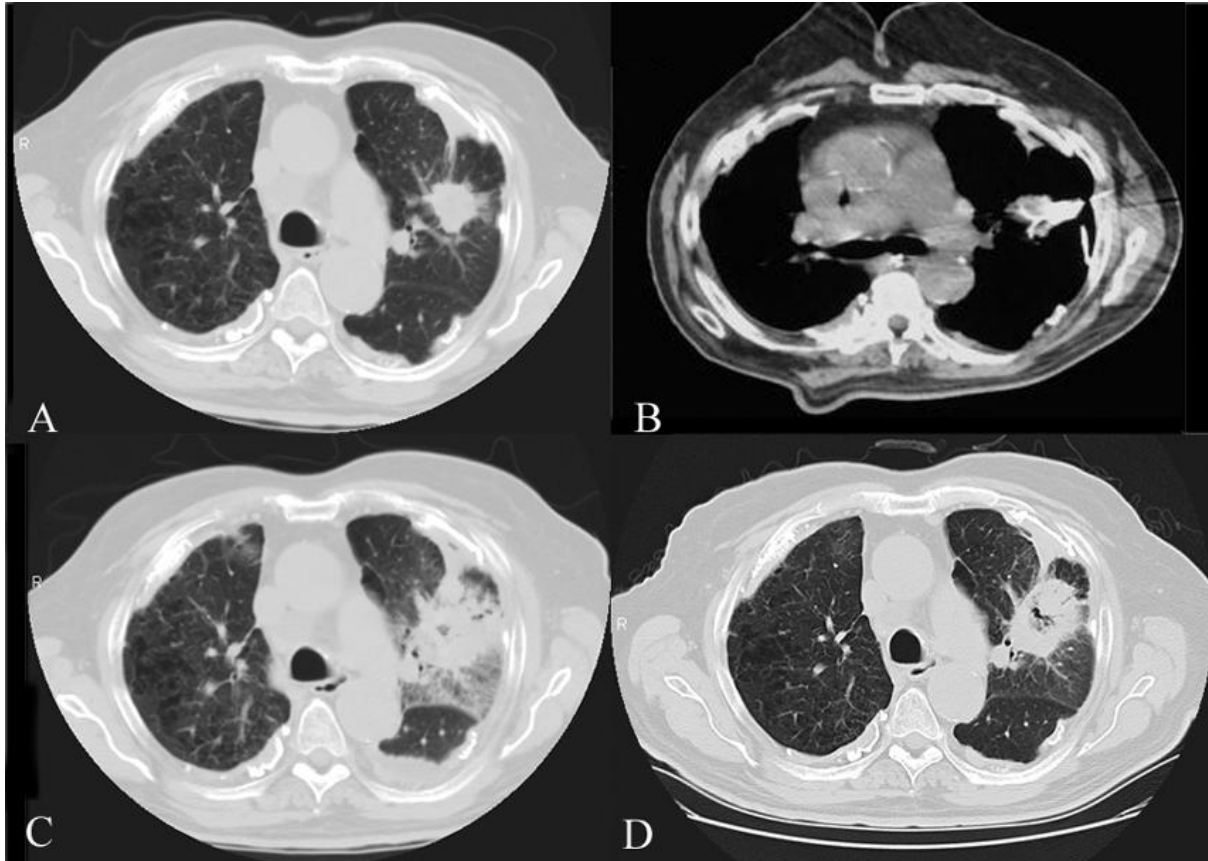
Treatment with percutaneous RFA of a left non-small cells lung carcinoma in a patient of 78 years. (A) CT image before the procedure revealed a 3cm mass in the left upper lobe lung. (B) Treatment with RFA guided by CT image (C) CT image 2 days after RFA showing inflammation and hemorrhage. (D) CT 3 months after the procedure reveals a central cavity and reduced density of the lesion.
